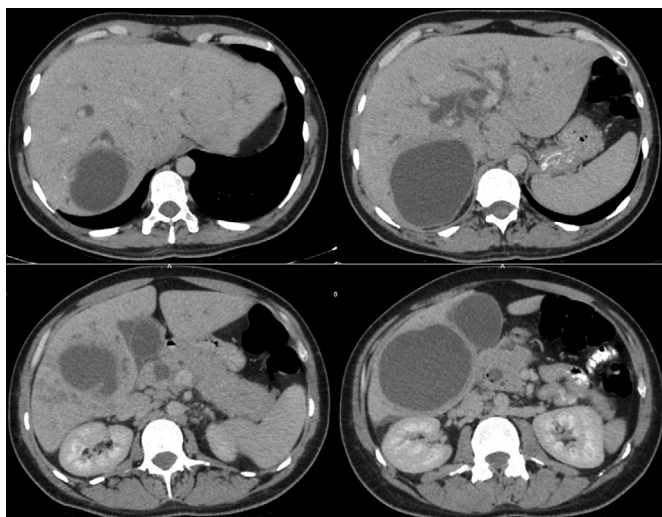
CT imaging of hydatid cysts and dilated intrahepatic biliary tracts.
